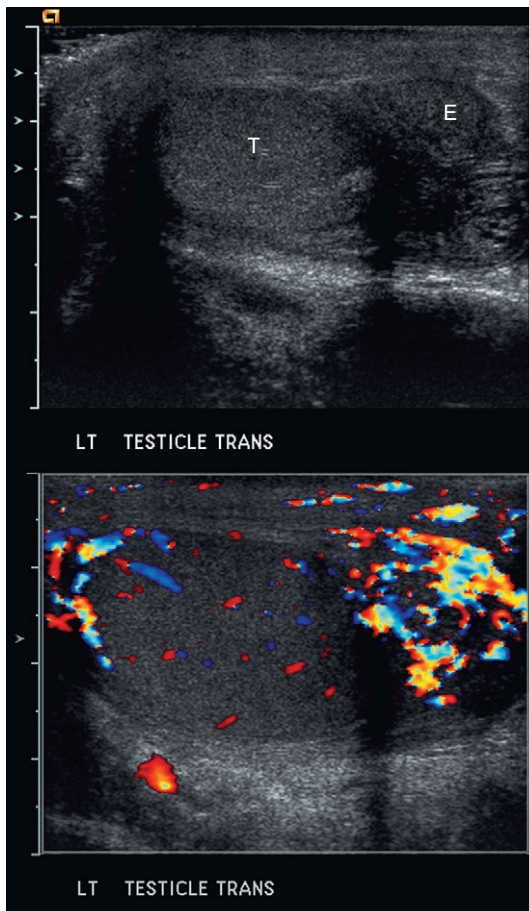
Longitudinal view of the left testicle with and without colour Doppler. The epididymis (E) is enlarged, but the testicle (T) remains of normal size and echotexture. With colour Doppler, there is brisk flow in the epididymis whereas the testicle shows appropriate if not slightly reduced flow. These findings are consistent with epididymitis.
